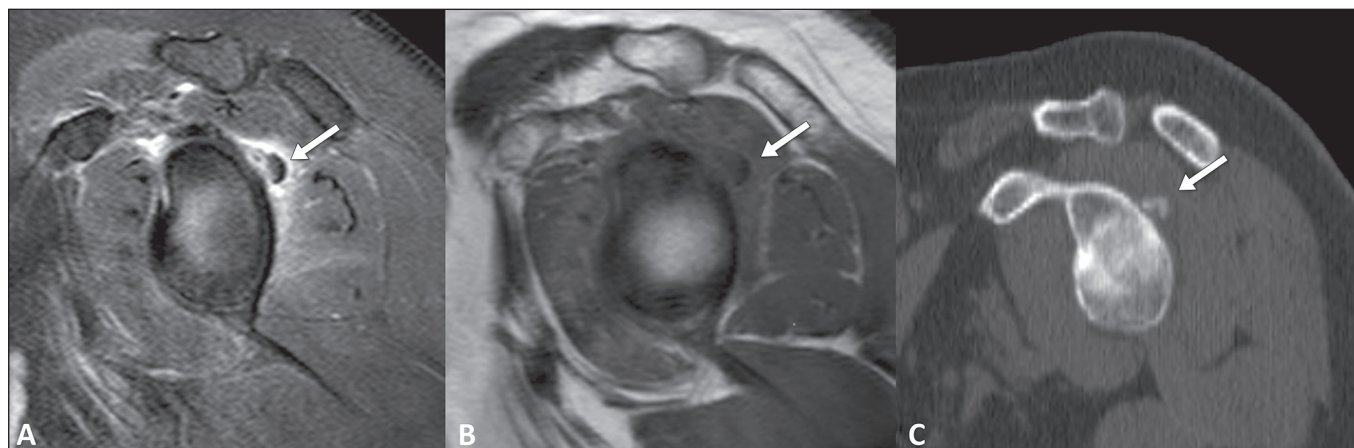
A 56-year-old female patient with a seven-day history of shoulder pain underwent magnetic resonance imaging and subsequent computed tomography. A: Sagittal T2 image with fat saturation showing low signal foci (arrow) in the posterosuperior capsulolabral region of the shoulder, with edema of adjacent soft tissues. B: Sagittal T1-weighted image showing foci with low signal intensity in the posterosuperior capsulolabral region (arrow). C: Sagittal computed tomography reconstruction demonstrating foci of calcification (arrow).
